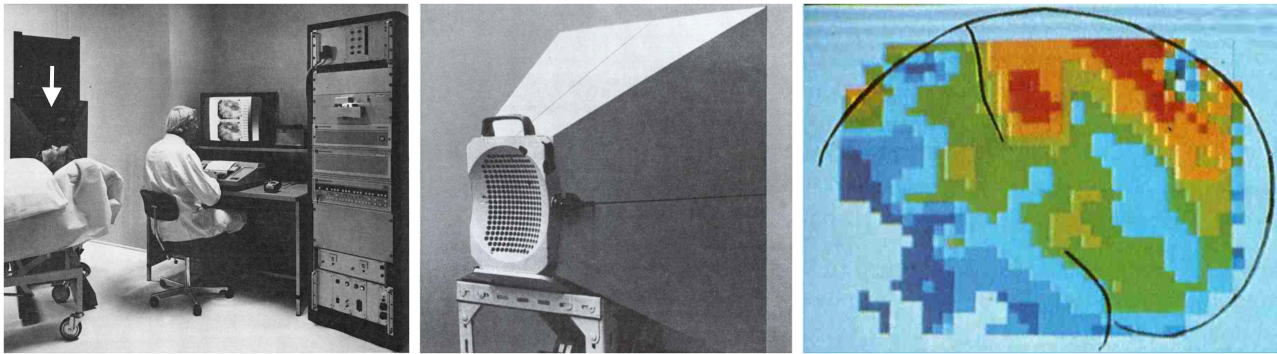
Functional neuroimaging in humans started with 2D scintigraphic imaging of cerebral blood flow. An experimental set-up is shown in the left panel. The arrow points to a gamma camera equipped with a cone beam collimator similar to the collimator shown in the middle panel. The cone-beam collimator is placed close to the subject's head. The gamma camera is a 254 detector camera developed by Per Rommer and Edda Sveinsdottir under the leadership of Niels A. Lassen at Meditronic and commercialized by Medimatic under the name "Dynamatic 254" (Images reprinted with permission from Per Rommer). An example of the images obtained with this set-up is shown in the right panel. Brain contours and the central sulcus are outlined in black. The image shows CBF during hand gripping with the contralateral hand. Reprinted with permission from the American Medical Association. Copyright © (1976) American Medical Association. All rights reserved [12].
